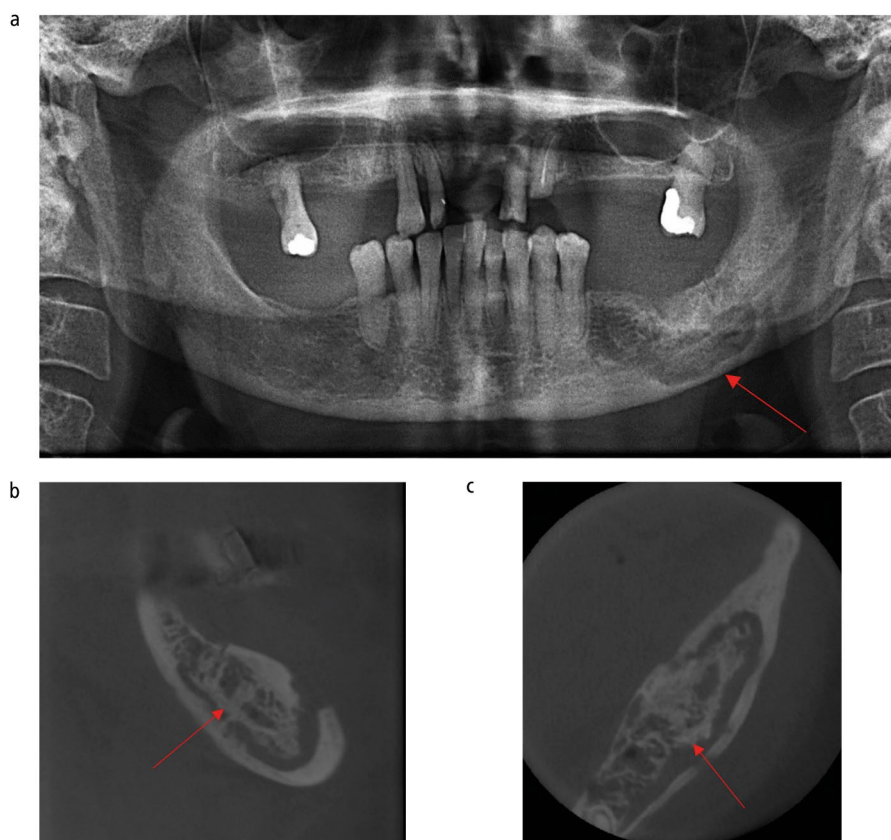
a) Dental panoramic tomograph demonstrating bone sclerosis and cortical erosion in the edentulous left posterior mandible. b, c) CBCT still images of the sagittal and axial plane, respectively, showing a mixed lucent and opaque area mirroring MRONJ with the lesion in fact being a breast metastatic deposit
